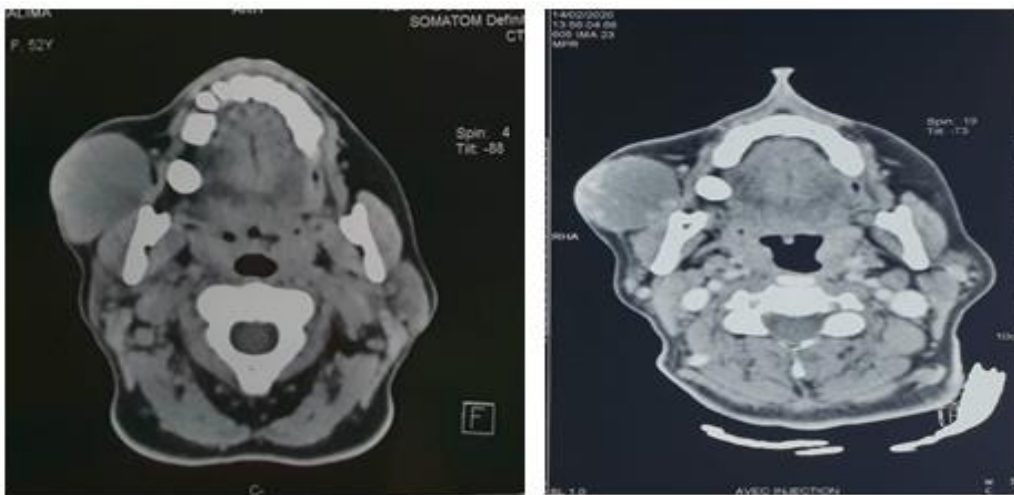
Axial contrast-enhanced computed tomography images shows a non-homogeneously enhancing mass in contact with masseter muscle.
